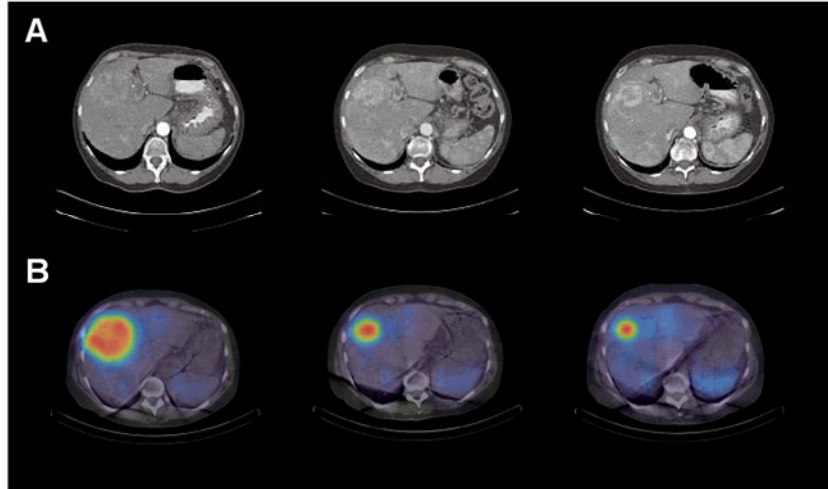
Example of dose response in a patient with inoperable metastasized PNET in the liver (Patient number 19). Figure A: Transversal contrast-enhanced CT images in the late arterial phase. Figure B: Fused SPECT/CT images. Left to right: Examinations at baseline, and after two and three cycles of PRRT.
